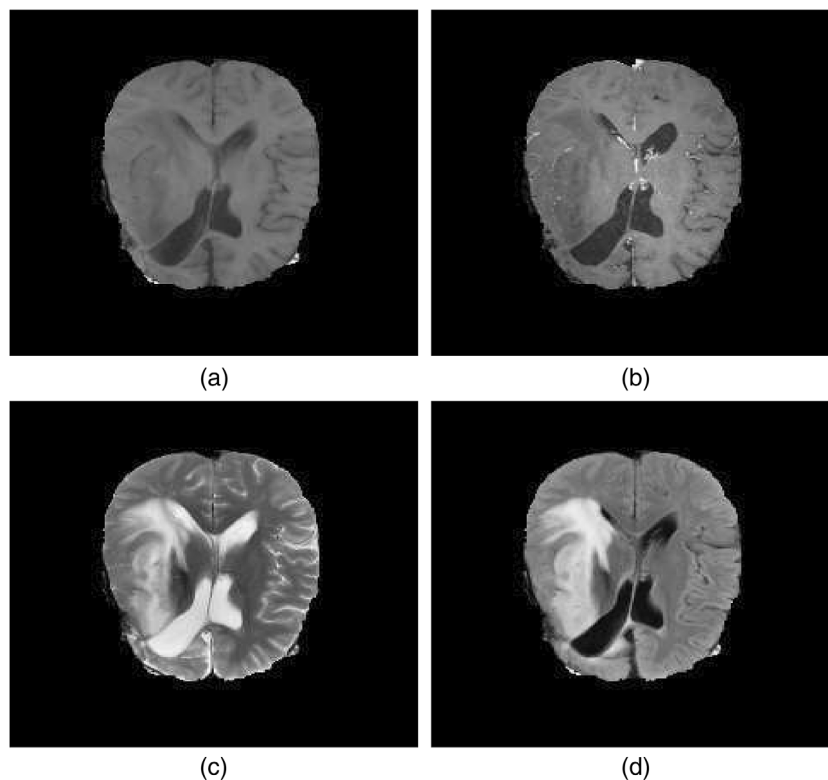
Four MRI sequence images from a patient (a) T1-weighted, (b) T1c-weighted, (c) T2-weighted, and (d) FLAIR
